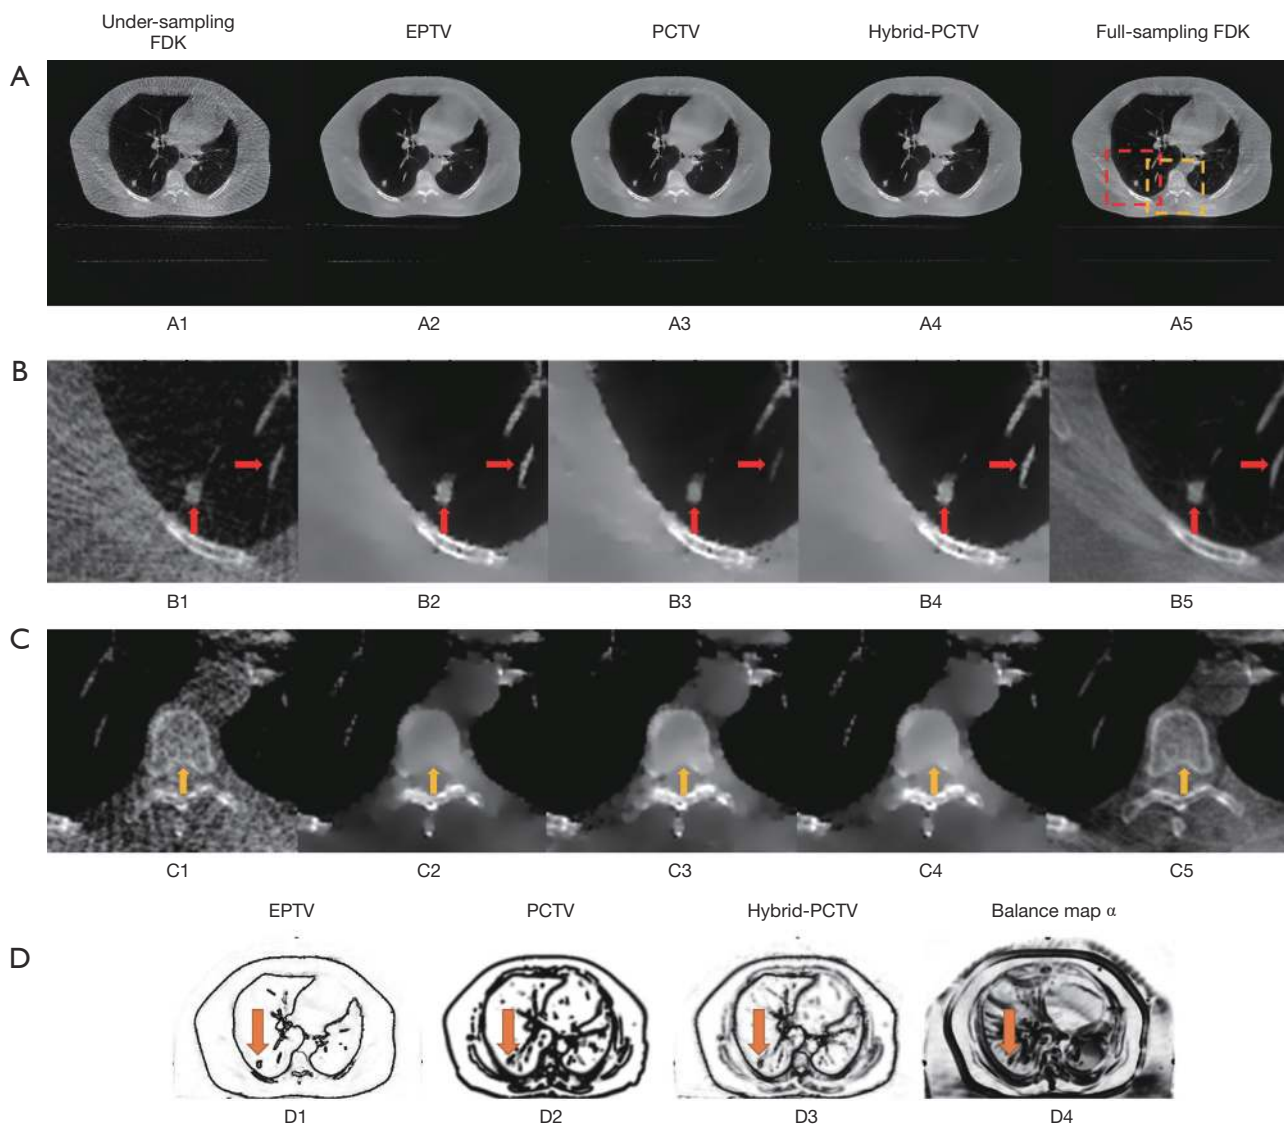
Reconstructed images of the lung using real CBCT projections. (A) Reconstructed images of the lung. From left to right: FDK (149 proj.), EPTV, PCTV, hybrid-PCTV and full sampling FDK (894 proj.) displayed in the window of (-800 HU, 600 HU). (B) Zoom in reconstruction images of clinical lung patient around the tumor region displayed in the window of (-800 HU, 200 HU) while (C) zoom in reconstruction images in the spine region displayed in the window of (-200 HU, 600 HU). Edge map comparisons: (D1) is the weight map of last reconstruction iteration in EPTV while (D2) is the weight map used in PCTV and (D3) is the weight map of last reconstruction iteration in hybrid-PCTV. (D4) is the balance map α based on SSIM to balance EPTV and PCTV edge during reconstruction. PCTV, prior contour based TV; EPTV, edge preserving TV.
